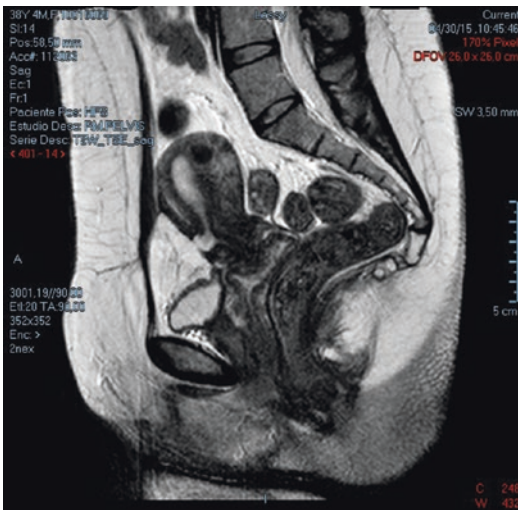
Myometrial defects as seen with MRI
